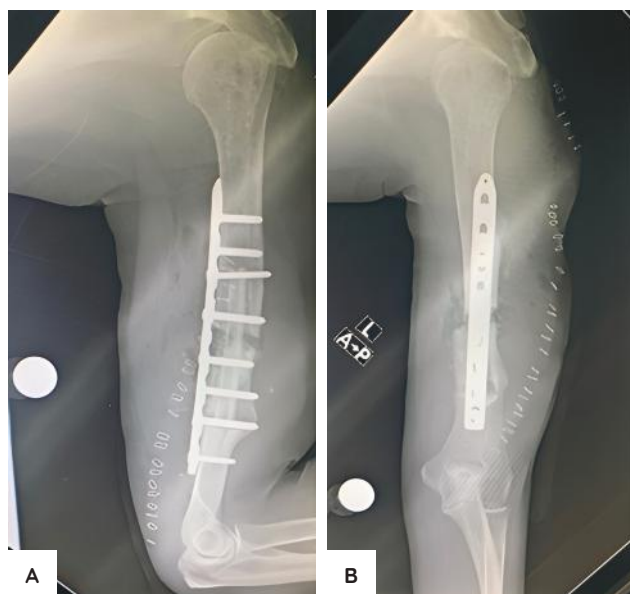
Postoperative x-rays of the left humerus in anteroposterior (A) and lateral (B) views, showing stable fixation of the fracture segments with an intramedullary strut graft bridging the fracture gap.
